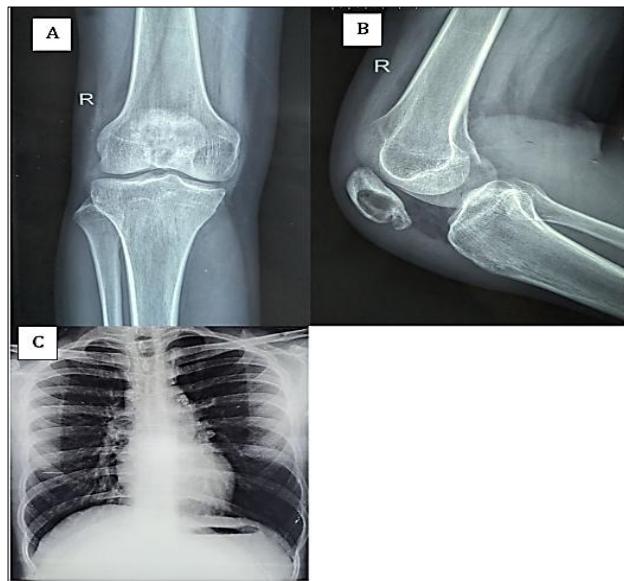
(A) Preoperative anteroposterior (AP) radiograph of the knee showing the patellar lytic lesion.
